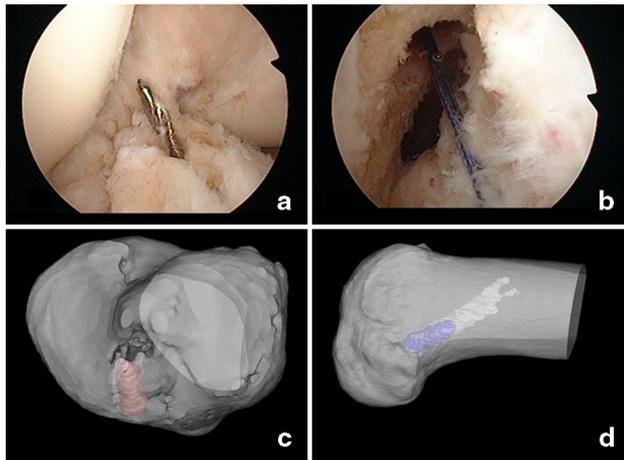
Conventional single-bundle ACL reconstruction in a right knee. a The tibial tunnel is located in the PL bundle insertion site (arthroscopic view). The femoral tunnel is located at the high-AM position, above the native ACL insertion site (arthroscopic view). c and d Tibial and femoral tunnel position on corresponding 3D CT scan
